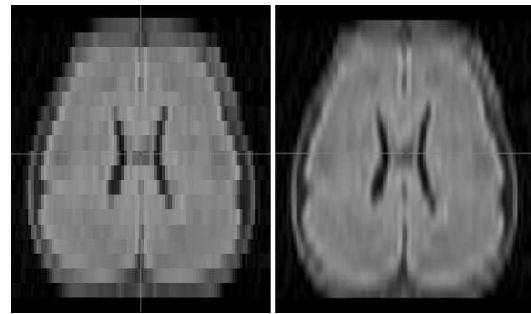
on the left the original MR image (z-direction), on the right the B-spline interpolated MR image.
